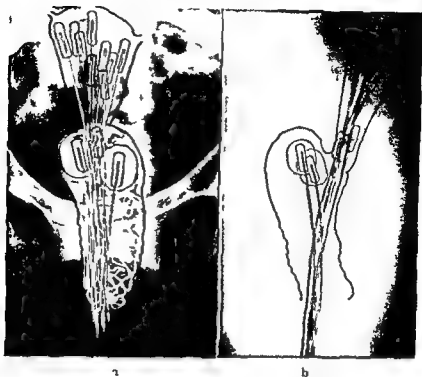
Carcinoma in a large uterine cavity packed with ten afterloading capsules: a) AP and b) lateral roentgenograms showing intrauterine capsules and afterloaded Manchester ovoids in vaginal fornices.
